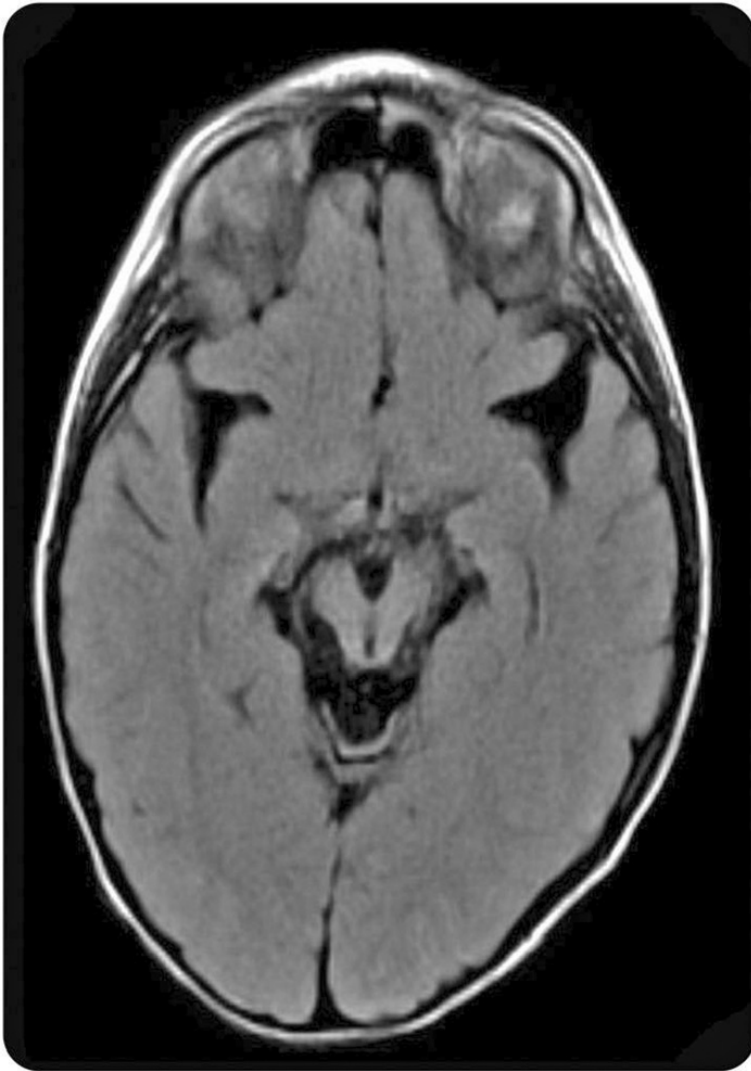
MRI in GABA-T deficiency. Axial MRI, FLAIR sequence, with prominent enlargement of the Sylvian fissures and pontomesencephalic cisterns. Reproduced with permission from Koenig MK, Hodgeman R, Riviello JJ, Chung W, Bain J, Chiriboga CA, et al. Phenotype of GABA-transaminase deficiency. *Neurology*. 2017;88(20):1919–24.
